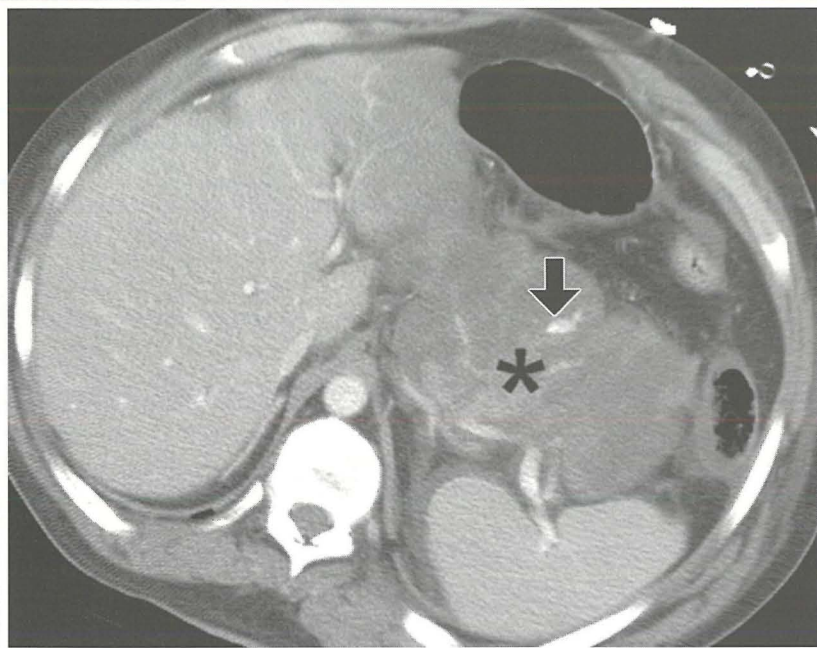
CT scan demonstrates hemorrhagic pancreatitis as a heterogeneous mass in the area of the pancreatic bed (*) that mimics a pancreatic tumor. Arrow indicates active haemorrhage
